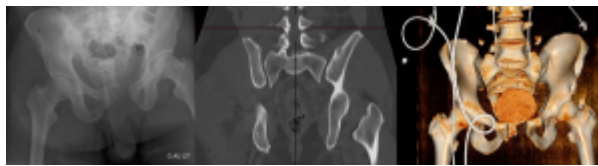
Example of translationally unstable C injuries with disruption of all posterior osteo-ligamentous structures and also of the pelvic floor. AP pelvic X ray, frontal CT reconstruction and 3D reconstruction. Images Pr. Boudissa.
